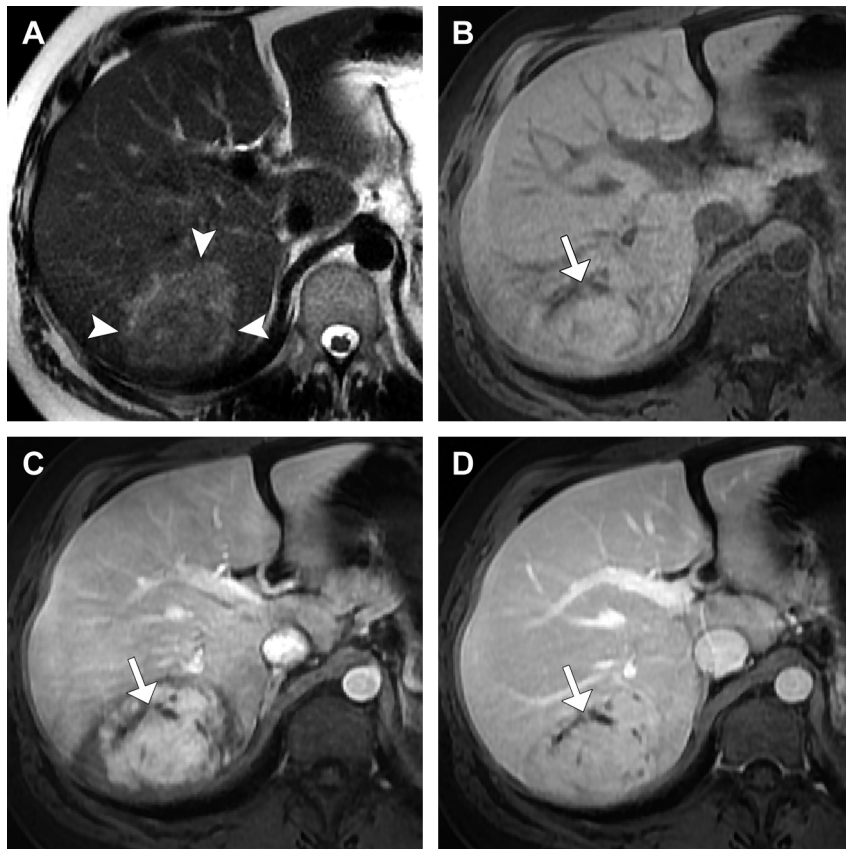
HCA (β -catenin-activated subtype) in a 31-year-old male. (A) Heterogeneous, mildly T2 hyperintense mass in the posterior right lobe has a peripheral band of mildly T2 hyperintense signal (*arrowheads*). (B) Precontrast fat-suppressed T1-weighted image demonstrates an eccentric poorly defined T1 hypointense scar (*arrow*). (C) The mass exhibits heterogeneous arterial hyperenhancement and slightly more uniform enhancement during portal venous phase (D) with exception of the nonenhancing eccentric scar (*arrows*). HCA with β -catenin mutation was found at resection. This subtype occurs more frequently in men. It has been suggested that vaguely defined scars or poorly defined T2 hyperintense areas within a lesion might relate to β -catenin activation, but this is not definitive and biopsy remains the best option for diagnosing this subtype.
